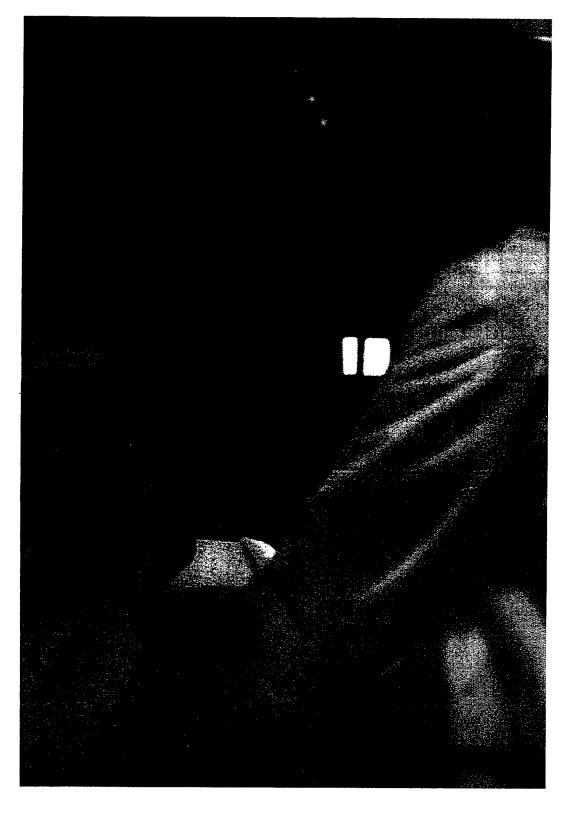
BAMC Cardiology Staff Performing Remote Echocardiograph Exam In LifeLink<sup>TM</sup> Ambulance
